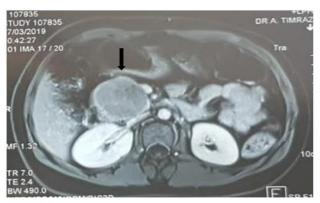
MRI showed a well-defined pancreatic tumor
